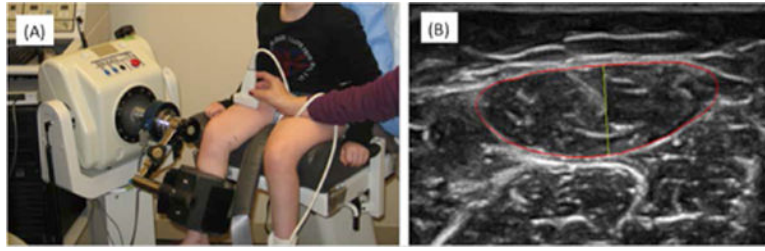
(A) Experimental setup for data acquisition. (B) Ultrasound image of the *rectus femoris*, with the muscle boundary outlined in red, and the thickness indicated in yellow.
